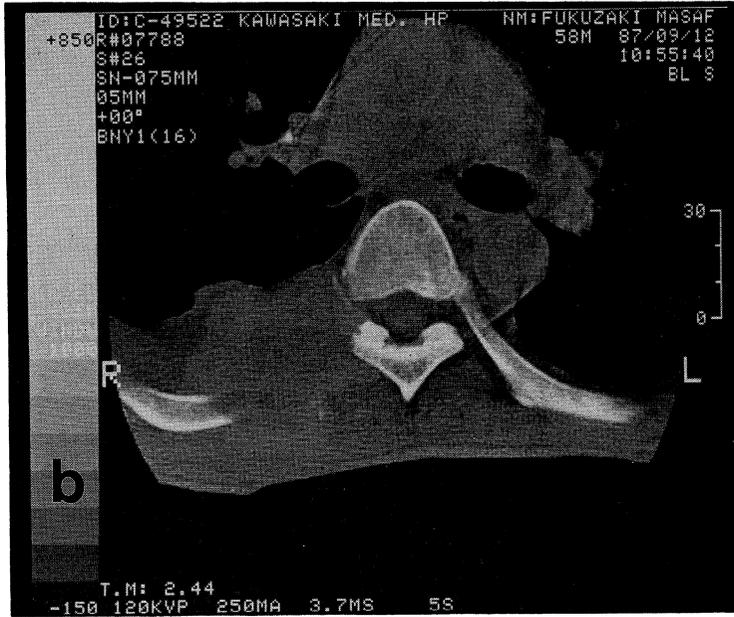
Computed tomography showed the soft tissue mass in the right rib.
